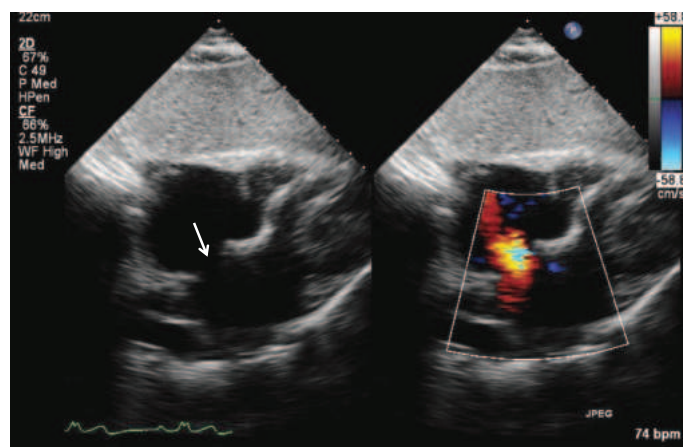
Large secundum-type atrial septal defect (*arrow*) noted in the subcostal view with color flow Doppler showing flow through the defect (*right*).
